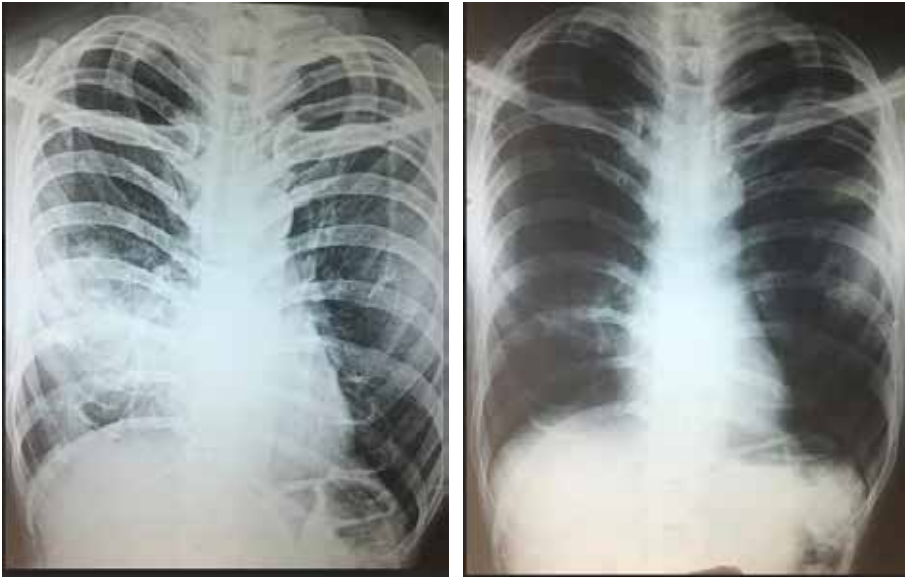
The radiograph to the left shows a right middle lobe pneumonia. The radiograph to the right is taken after antibiotic course and shows near total resolution of the consolidation.
